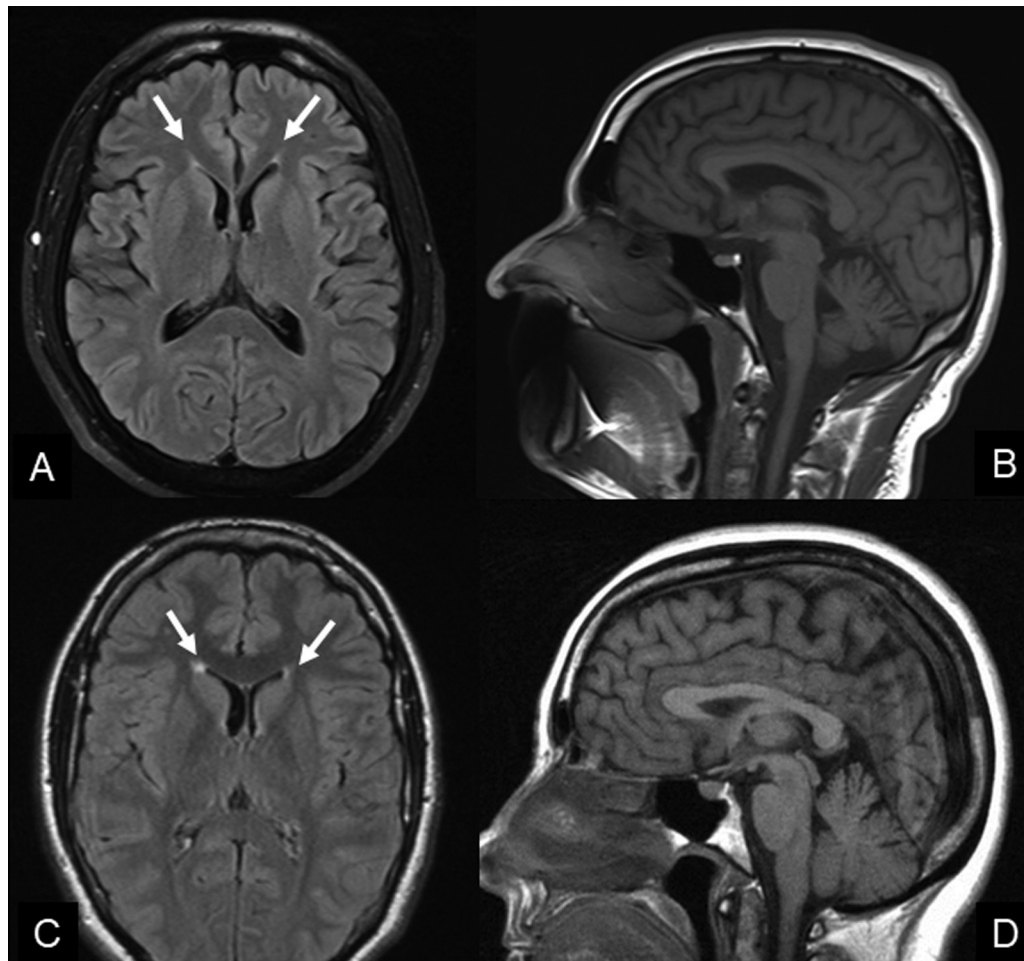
(A) Axial fluid attenuated inversion recovery (FLAIR), with white arrow showing the “ears of the lynx” sign and (B) Sagittal T1 showing cerebellar atrophy. Both (C) and (D) show a normal examination with an important differential diagnosis of “Ears of the lynx” signal, ependymitis granularis, which is usually more rounded and subtle.
